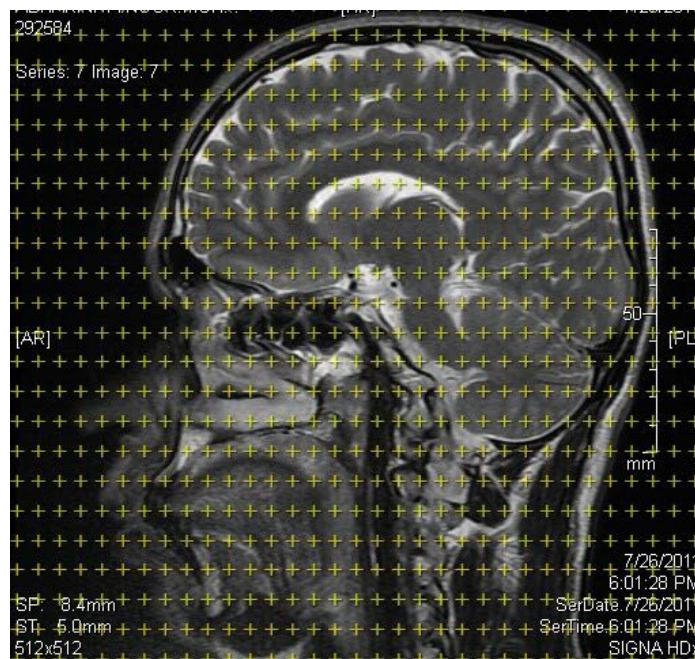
The points counting technique on a sagittal brain MRI using stereological method
